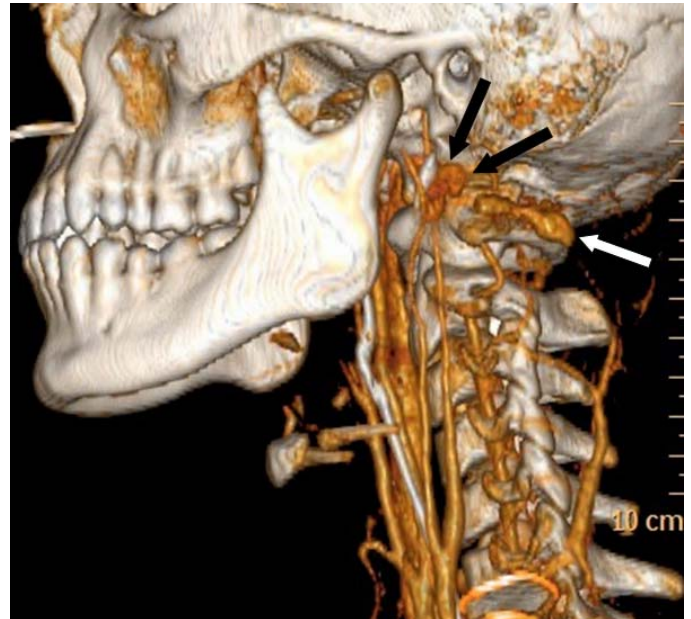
Three dimensional reformatted image of CT Angiogram showing the internal carotid pseudoaneurysm (black arrows) and small vertebral pseudoaneurysm (white arrow).
